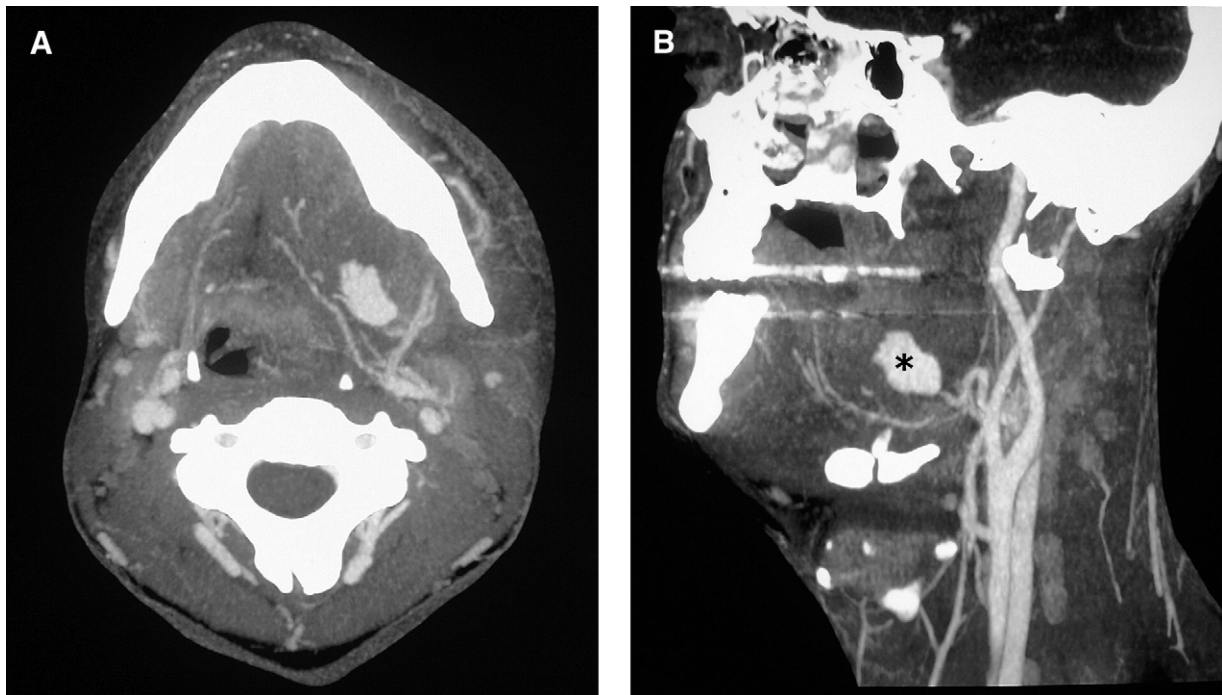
CT angiogram and 3D volume-rendered reconstructions in a 25-year-old man after dental extraction. Axial MIP image (A) and 3D volume-rendered reconstruction (B) show pseudoaneurysm (*) emanating from left facial artery. Note also displacement of the airway due to the pseudaneurysm and the surrounding hematoma.
